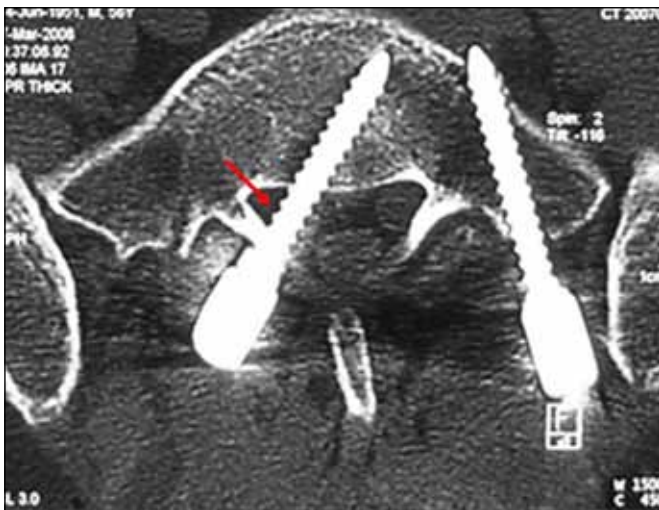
A postoperative CT scan shows malpositioning of the right L5 screw (red arrow).
